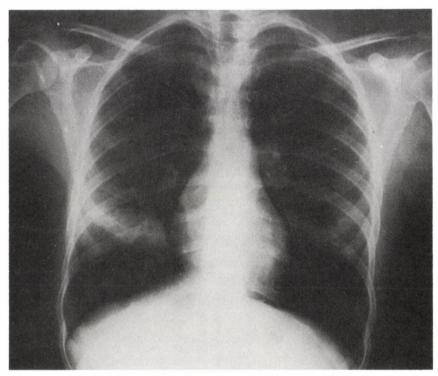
P-A X-Ray: ruptured cyst in the right lower lobe
